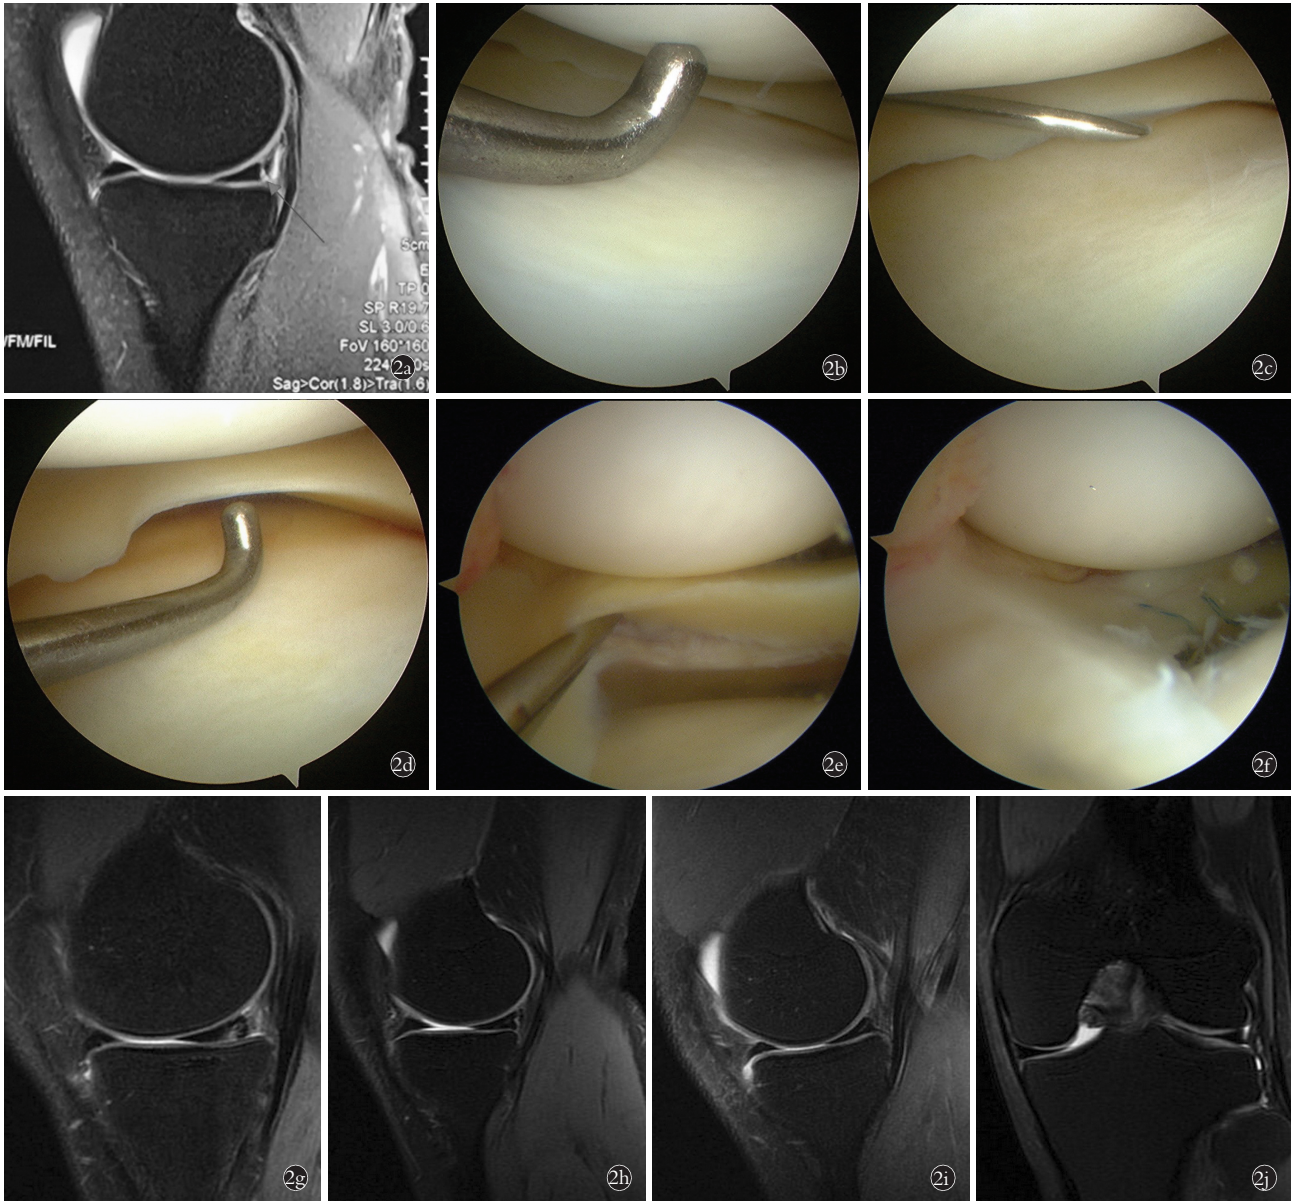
患者,男,24 岁,左膝内侧半月板撕裂 2 个月 2a. 术前 MRI 示内侧半月板后角纵裂(箭头) 2b. 膝外翻关节镜检查示内侧间室狭窄,开口小于探针尖宽度 2c. 术中采用由外向内经皮穿刺内侧副韧带深层松解技术,见 18 G 硬膜外针头穿过内侧副韧带深层进入关节腔 2d. 经皮穿刺内侧副韧带深层松解后即刻关节镜检查示内侧间室开口良好,探针操作空间宽敞 2e. 内侧关节间隙张开到能够完整显露内侧半月板后角的结构和撕裂范围 2f. 术后即刻关节镜检查示后内侧半月板修复 2g. 术后 3 个月矢状位 MRI 示内侧半月板后角修复区域高信号水肿带 2h. 术后 12 个月矢状位 MRI 示内侧半月板后角修复区域线性高信号区域贯通下表面,提示不完全愈合 2i. 术后 24 个月矢状位 MRI 示内侧半月板后角修复区域线性高信号区域,考虑瘢痕修复所致 2j. 术后 24 个月冠状位 MRI 示内侧半月板无外凸
